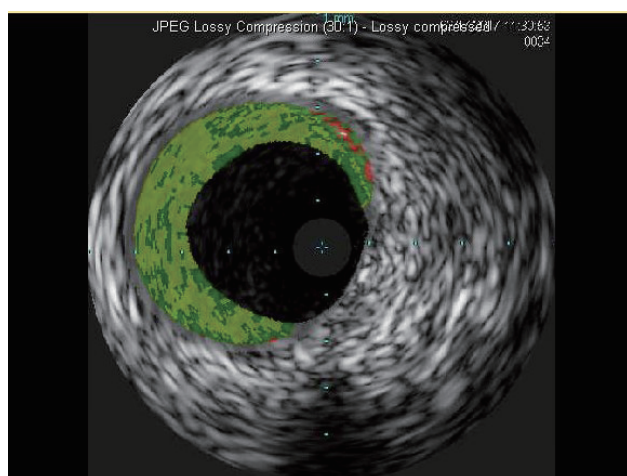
Intravenous ultrasound 12 months following the second transplant, showing CAV grade 0 and ISHLT grade 0.
